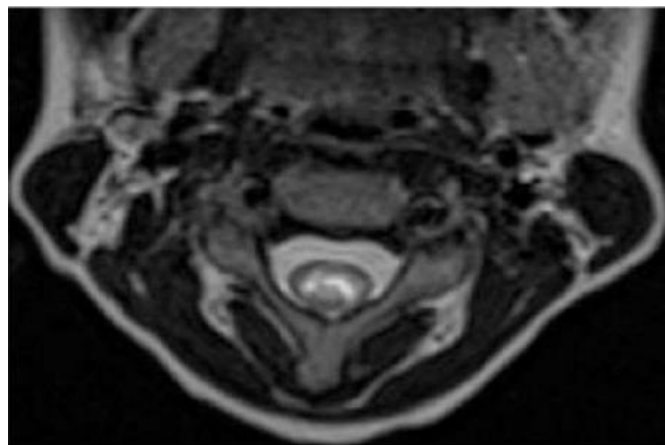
Cervical axial spinal MRI shows T2 hyperintense lesion at C2 level.
